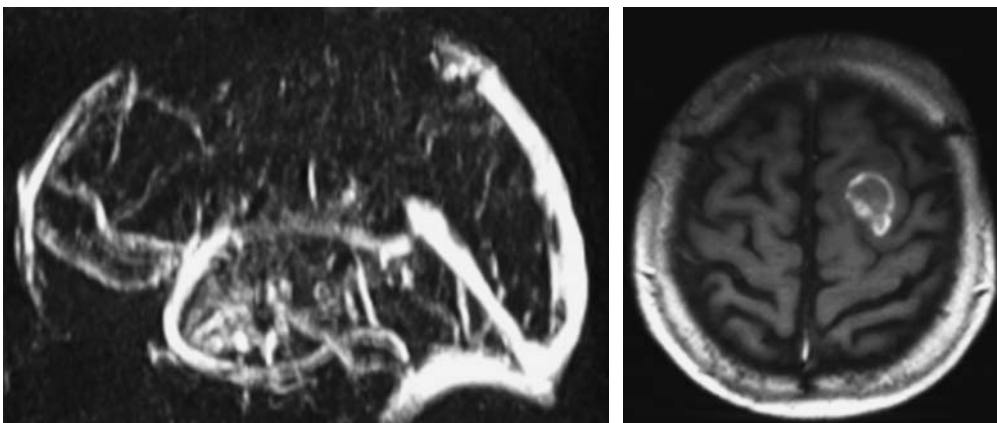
Patient with cerebral venous thrombosis. Venous MRA demonstrates occlusion of the sagittal sinus. MRI shows an intracranial hemorrhage, the typical complication of cerebral venous thrombosis. (Courtesy of Prof. von KUMMER)
